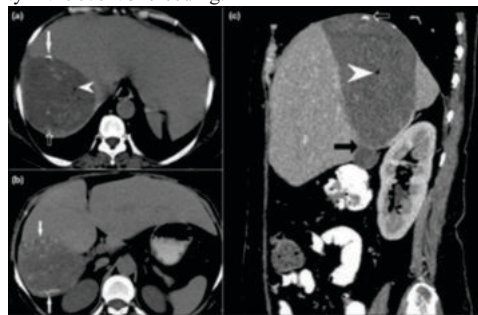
Lipid material in type II hepatic hydatid cyst. Axial contrast-enhanced CT image through the superior part of the liver shows well-defined cyst in the right lobe with fat attenuation areas within suggestive of biliary communication
